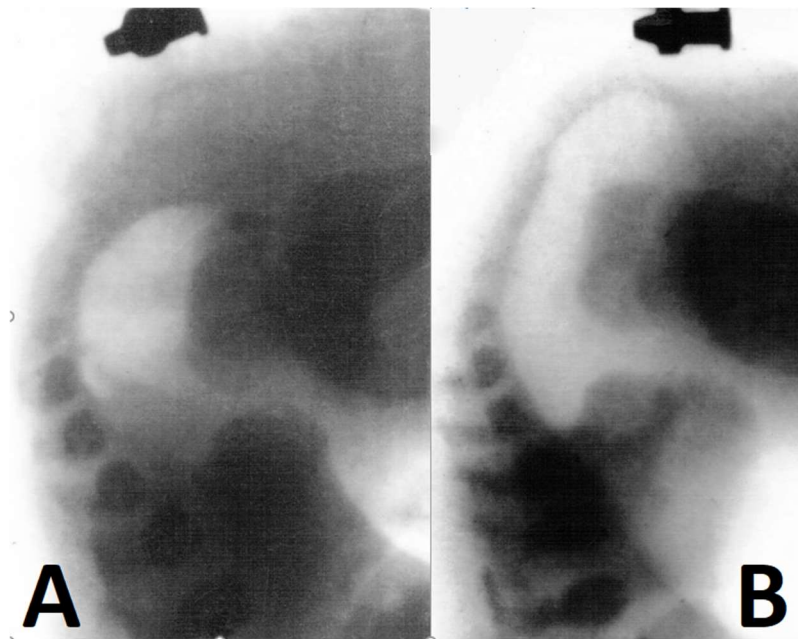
Lateral radiographs of a newborn boy with ARM, made in a horizontal position. (A). At rest. (B) . During abdominal compression, as a result of the reflex opening of the anal canal, the distal anal wall approached the anal dimple. The distance between the marker in the anal dimple and the caudal wall of the anal canal is 2 mm. Conclusion: low type of ARM.
